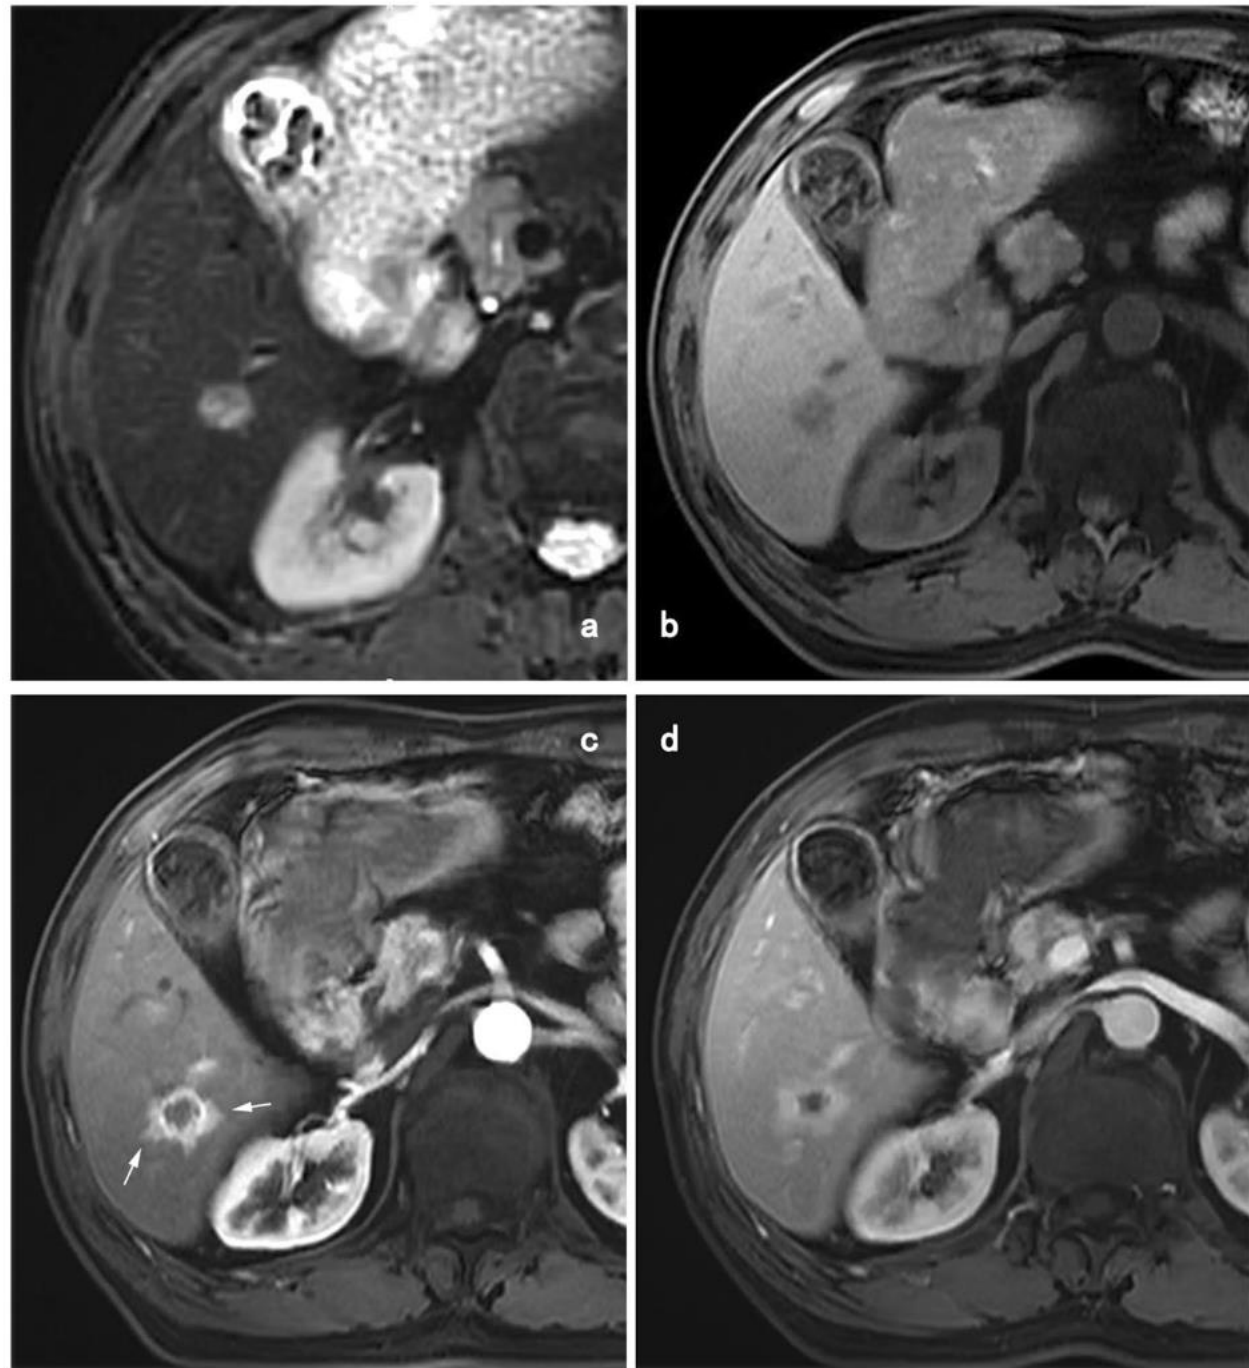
MR images in a 59-year-old man with classical ICC. Axial a T2-weighted, b precontrast T1-weighted, c arterial phase, and d portal phase gadolinium-enhanced MRI scans. Tumor (longest-diameter, 15 mm) with a lobulated margin exhibits hyperintensity on T2-weighted image (a), hypointensity on pre-contrast T1-weighted image (b), rim hyperenhancement on arterial phase image (c), and persistent enhancement on portal phase (d). The area peripheral to the tumor shows wedge-shaped enhancement on arterial phase image (arrows in c). There is no biliary dilatation or liver capsular retraction. ICC Intrahepatic cholangiocarcinoma
